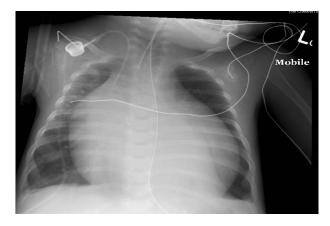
Chest x-ray showing gross cardiomegaly due to a hypertrophic and dilated cardiomyopathy in a 4-week-old infant with Pompe disease (infantile glycogen storage disease type II).
